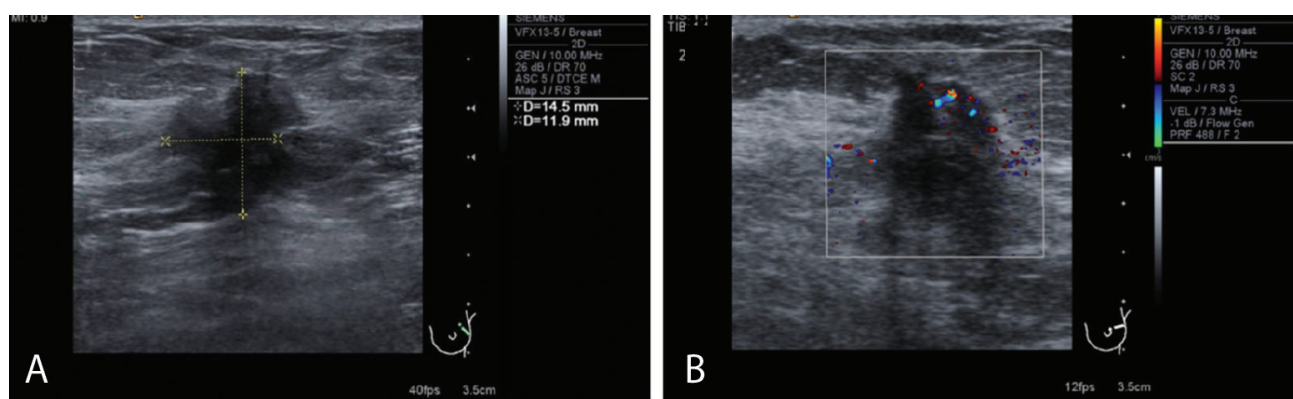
This figure shows the ultrasound of left breast showing ill-defined spiculated taller than wider hypoechoic lesion at 2-3 O'clock position on image A with posterior shadowing and internal vascularity (image B) correlating with lesion seen on MRI.
